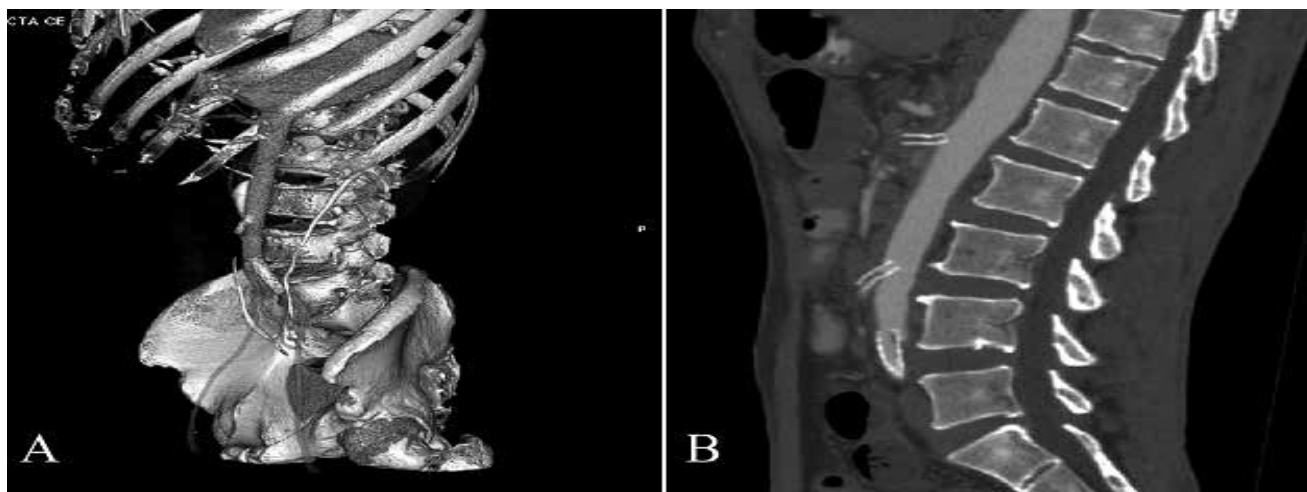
Preoperative 3 dimensional (A) and sagittal view (B) of CTA showing total occlusion of all the three main visceral vessels. Notice the patent stent in left common iliac artery.
